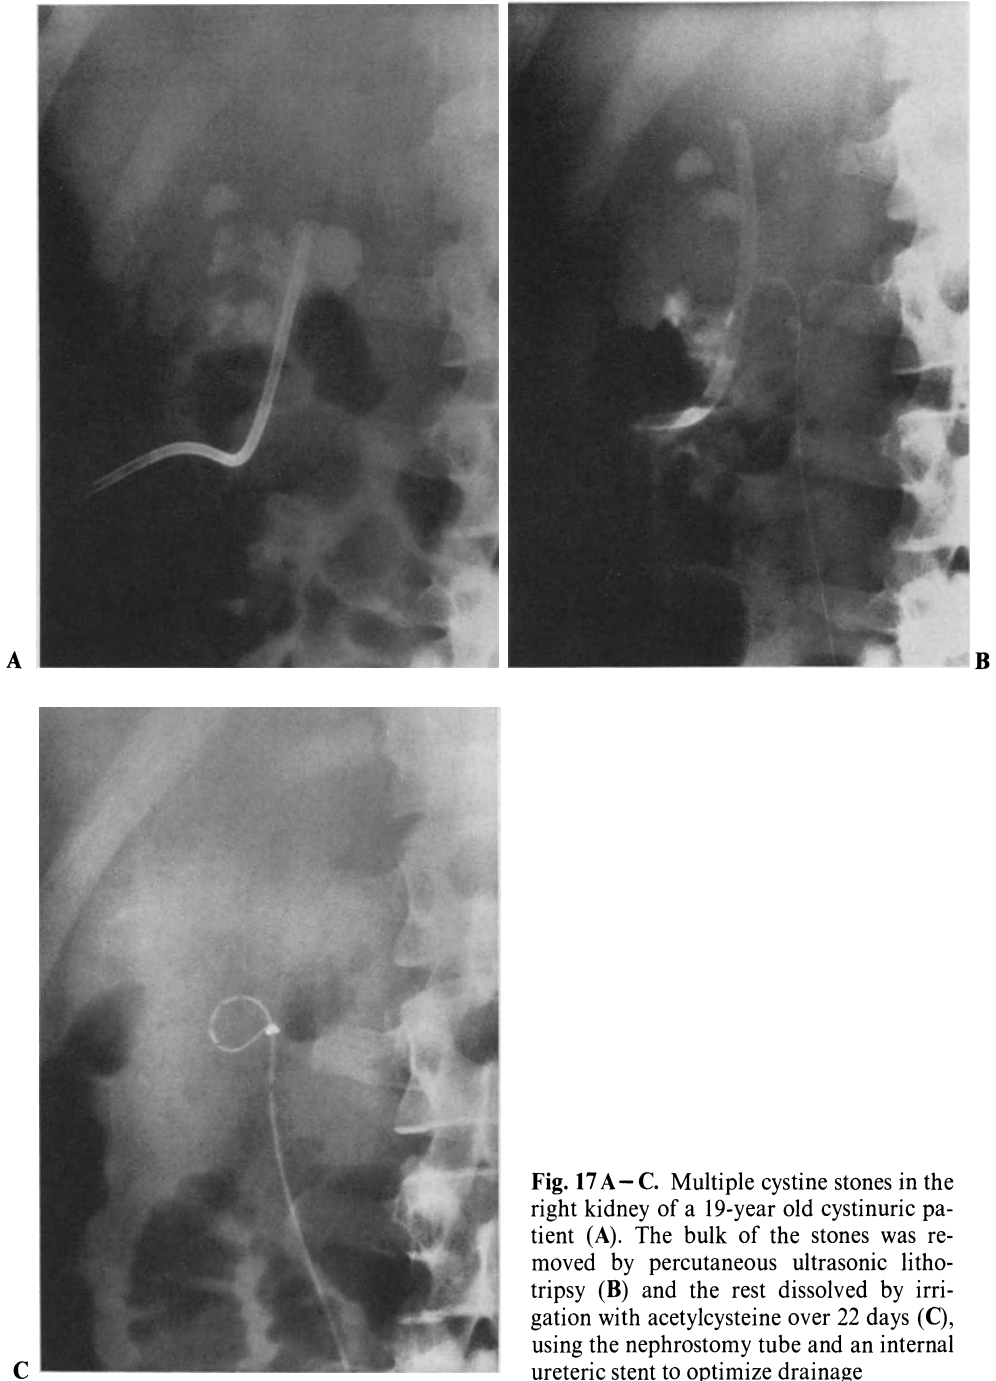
A–C. Multiple cystine stones in the right kidney of a 19-year old cystinuric patient (A). The bulk of the stones was removed by percutaneous ultrasonic lithotripsy (B) and the rest dissolved by irrigation with acetylcysteine over 22 days (C), using the nephrostomy tube and an internal ureteric stent to optimize drainage
